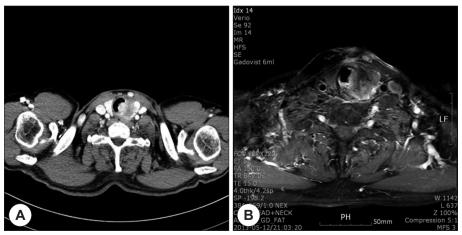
Radiologic findings. A heterogeneous enhancing mass is located in the left thyroid lobe with tracheal invasion evident in the(A) axial view of contrast-enhanced CT, and an(B) axial view of gadolinium-enhanced T1-weighted MR images.
